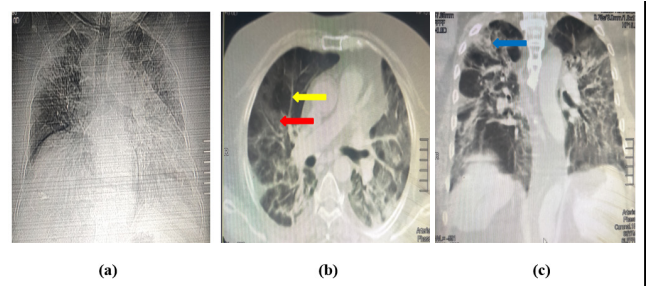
A 56-year-old male; (a) CXR, AP view (b) Chest CT, Axial view (c) Chest CT, coronal view
